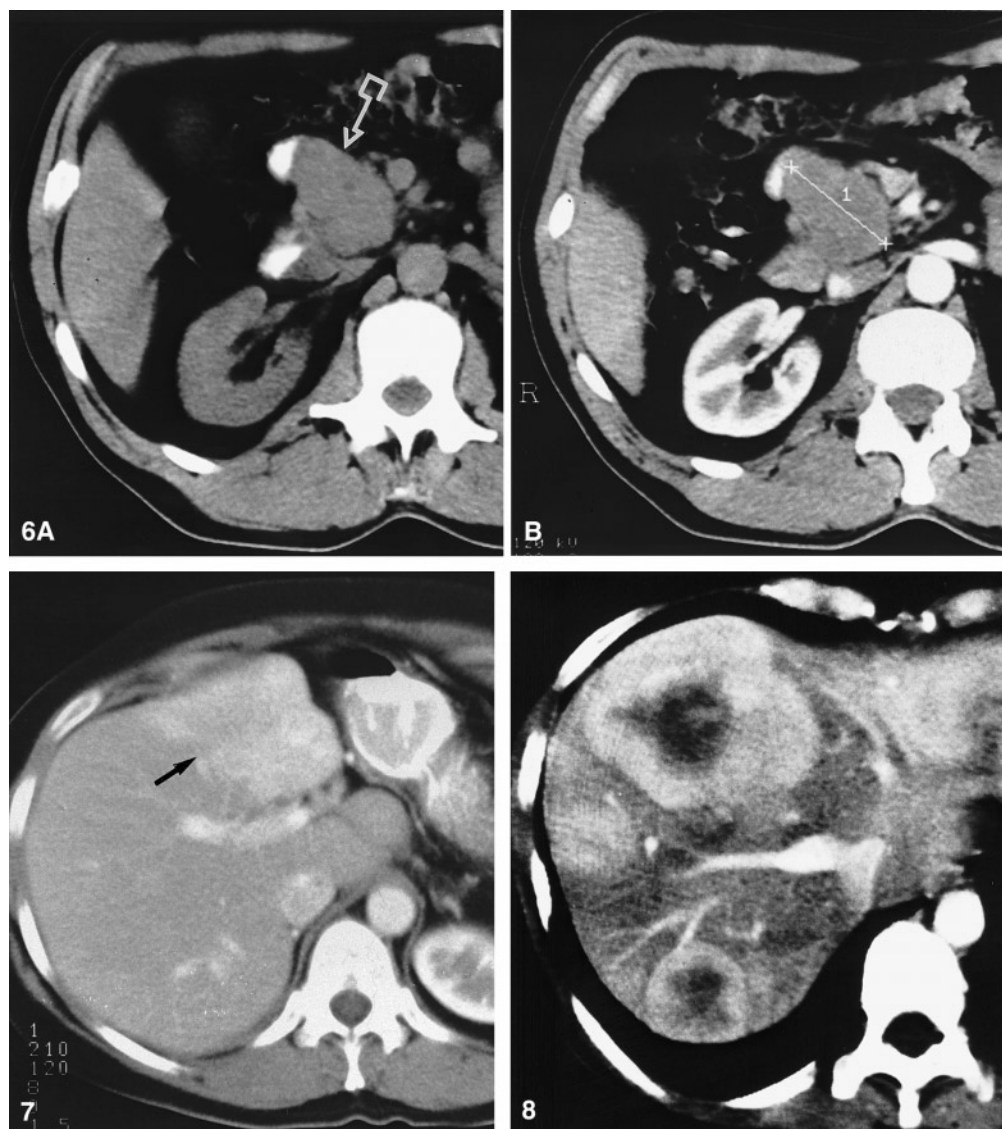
A 66-year-old man with primary carcinoid tumor of the pancreatic head. A On unenhanced CT, the tumor (*arrow*) is isoattenuated relative to the pancreatic parenchyma. The duodenum is markedly displaced. B The tumor shows homogeneous enhancement after intravenous administration of iodinated contrast material. These features are different from those commonly observed with pancreatic adenocarcinoma, which is more likely to appear hypoattenuated.
